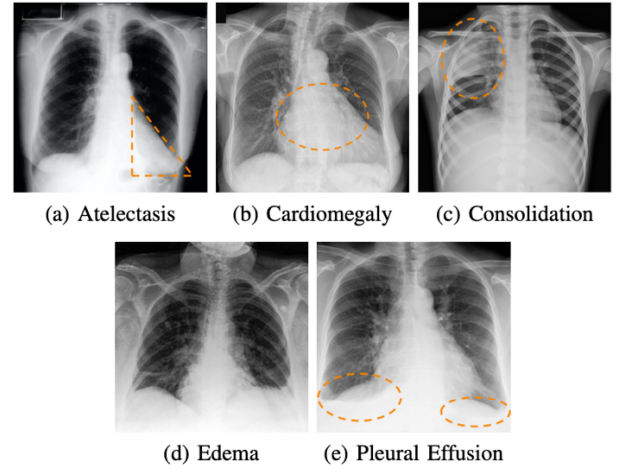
Sample x-ray images of the 5 pathologies.
